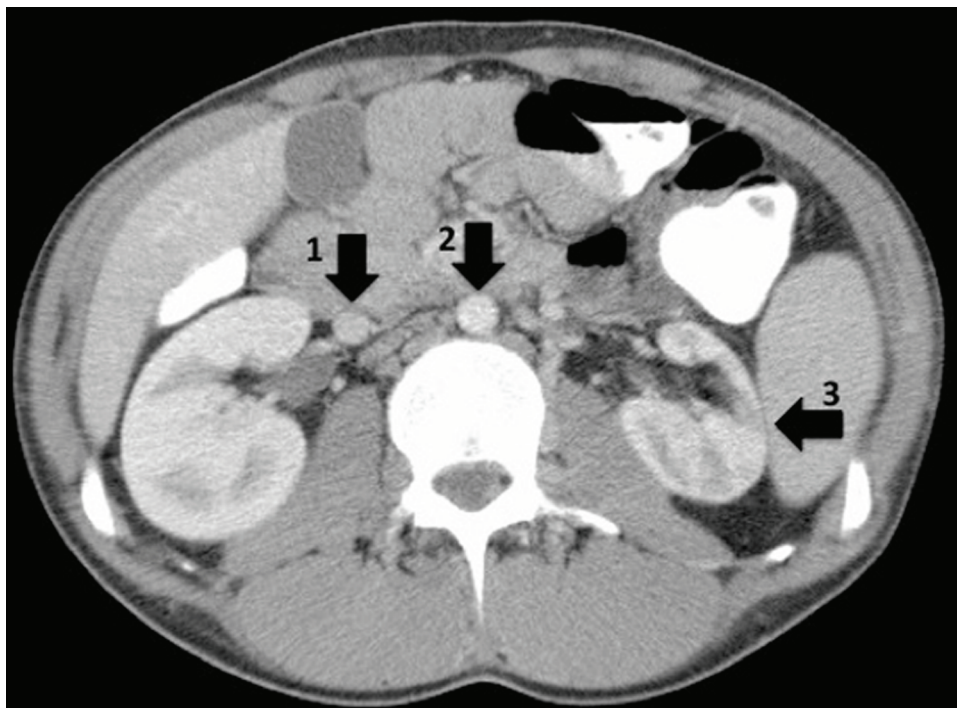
CT scan: Enlarged right subcardinal vein (1), Aorta (2), Agenesis of the left kidney (3).
